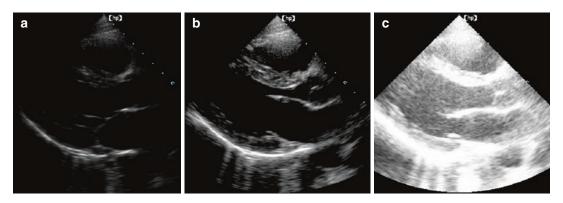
(a-c) Parasternal long-axis view demonstrating the effect of gain on an image. Insufficient gain is seen in "a", sufficient gain in "b" while the image in "c" is over gained destroying resolution
